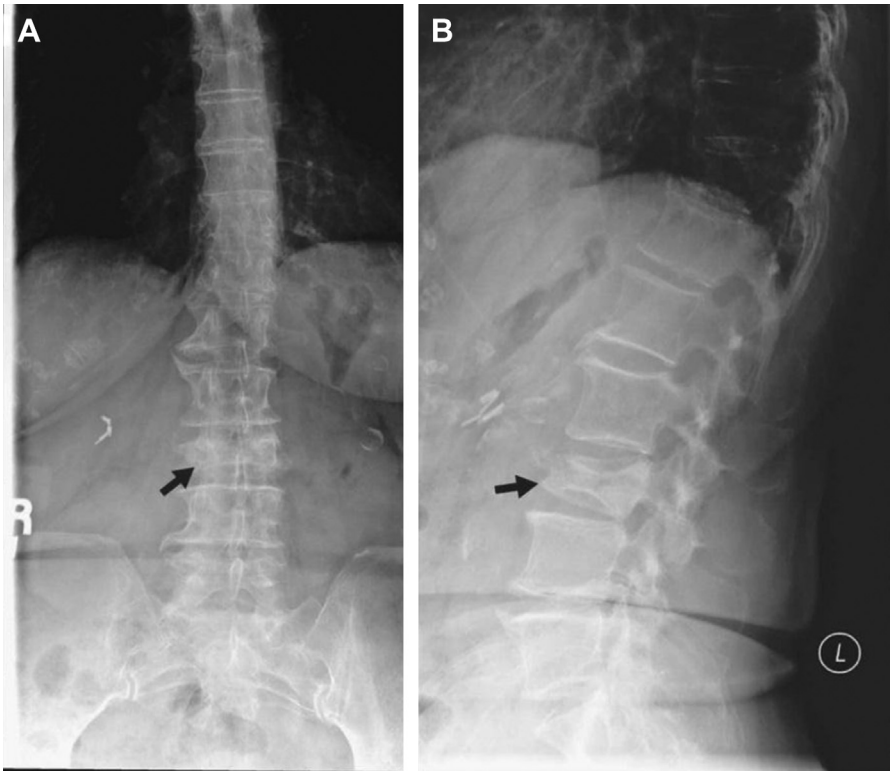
Radiograph of vertebral compression fracture. Anteroposterior (A) and lateral (B) radiographs of the lumbar spine showing an L3 vertebral compression fracture in an 86-year-old woman with a history of osteoporosis. Arrows are pointing to the fractured L3 vertebral body. (From Varacallo MA, Fox EJ. Osteoporosis and its complications. Med Clin North Am 2014;98(4):817–31; with permission.)
